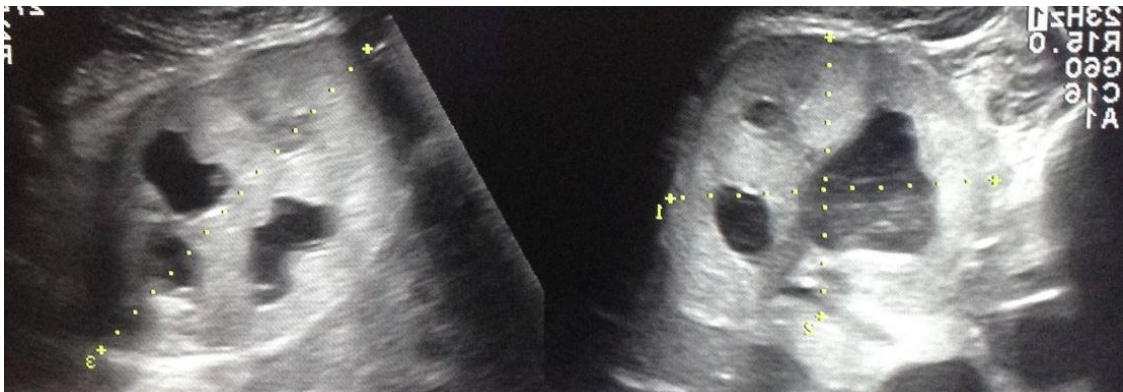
ultrasound scan of a kidney in a 72 year old male patient with 3years history of obstructive uropathy due to enlarged prostate. There is loss of corticomedullary differentiation, echogenic cortex, moderate thinning of the renal cortex and dilated calyceal system.
